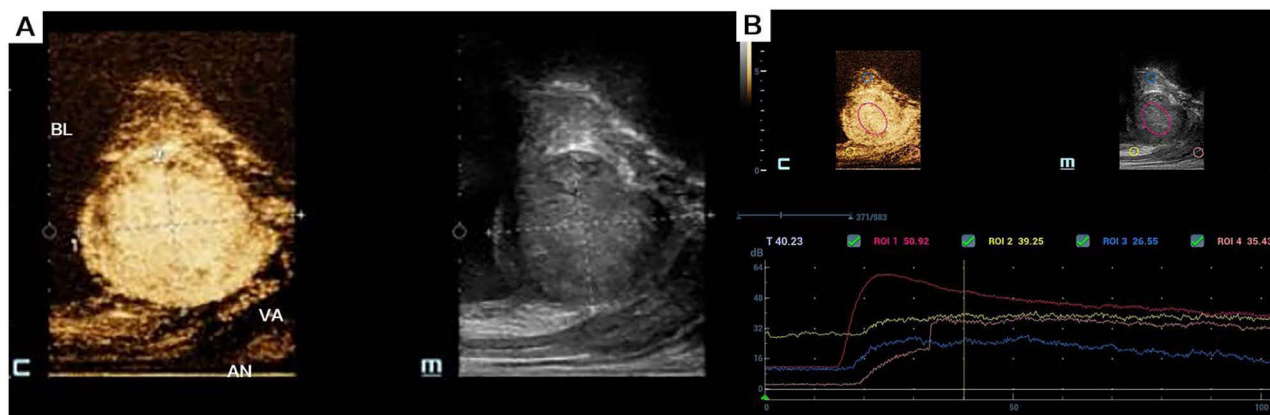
Transrectal (wire-array probe) ultrasonography: slight increase in volume in contrast mode compared to gray scale, see that the lower wall of the bladder is also infiltrated with contrast, consider infiltration (A), the mass is fast-entering and fast-exiting with high enhancement (B).
